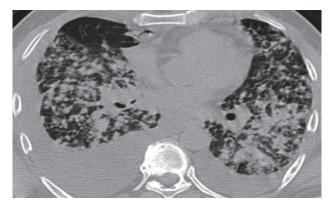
CT chest shows multiple small nodular dense opacities are seen in both lungs with bilateral effusion and hilar adenopathy in a case of pneumoconiosis
